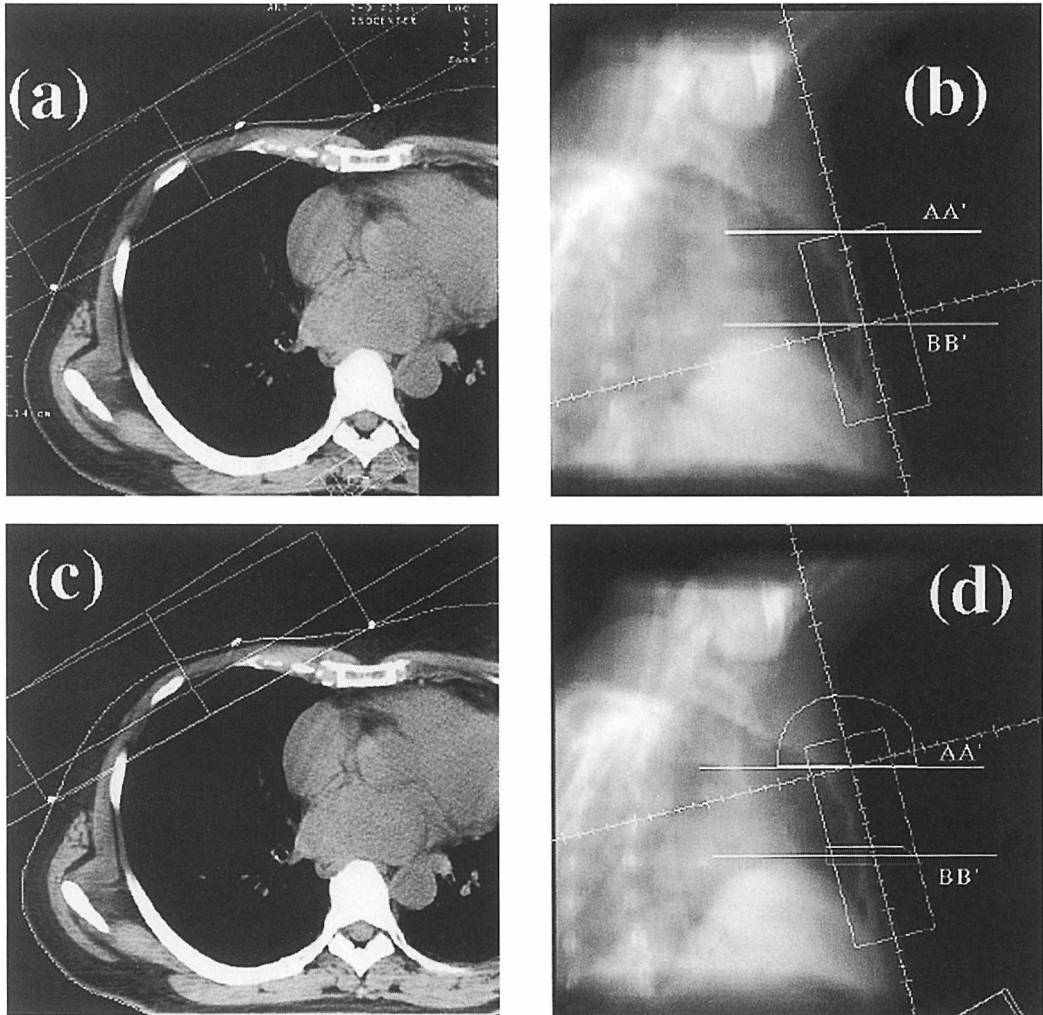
Part (a) shows the transverse CT section along the mid-tangential plane (BB' of Figure 1) with the isocenter located on BB', as well as the lateral radio-opaque markers. Part (b) shows the corresponding DRR and beam geometry. The transverse CT section along the mid-tangential plane (BB') with the isocenter located on AA' of Figure 1 is shown in part (c), and the corresponding DRR and beam geometry is shown in part (d).
